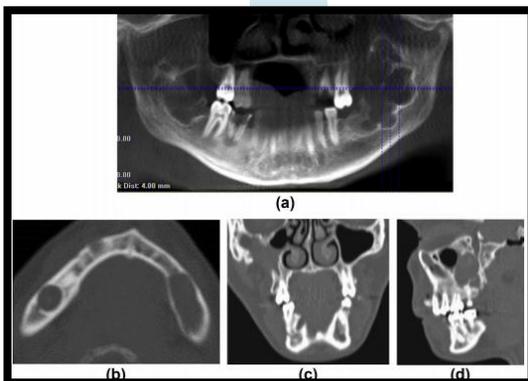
Panoramic reconstruction of CBCT of cherubism in a teenager. It displays lesions affecting the mandible and the left posterior maxilla. The most obvious lesions are the bilateral radiolucencies with corticated margins in the posterior sextants of the mandible. The lesion on the left is multilocular. The grossly carious right mandibular first molar also displays a periapical radiolucent lesion of inflammatory origin. (bed) Axial, coronal, and sagittal reconstructions of CBCT display multiple keratocystic odontogenic tumours in a case of NBCCS.
